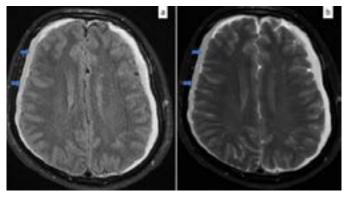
Axial FLAIR (a) and axial T2WI (b) bilateral subdural hemorrhage (arrows) are seen in the cerebral convexity.
